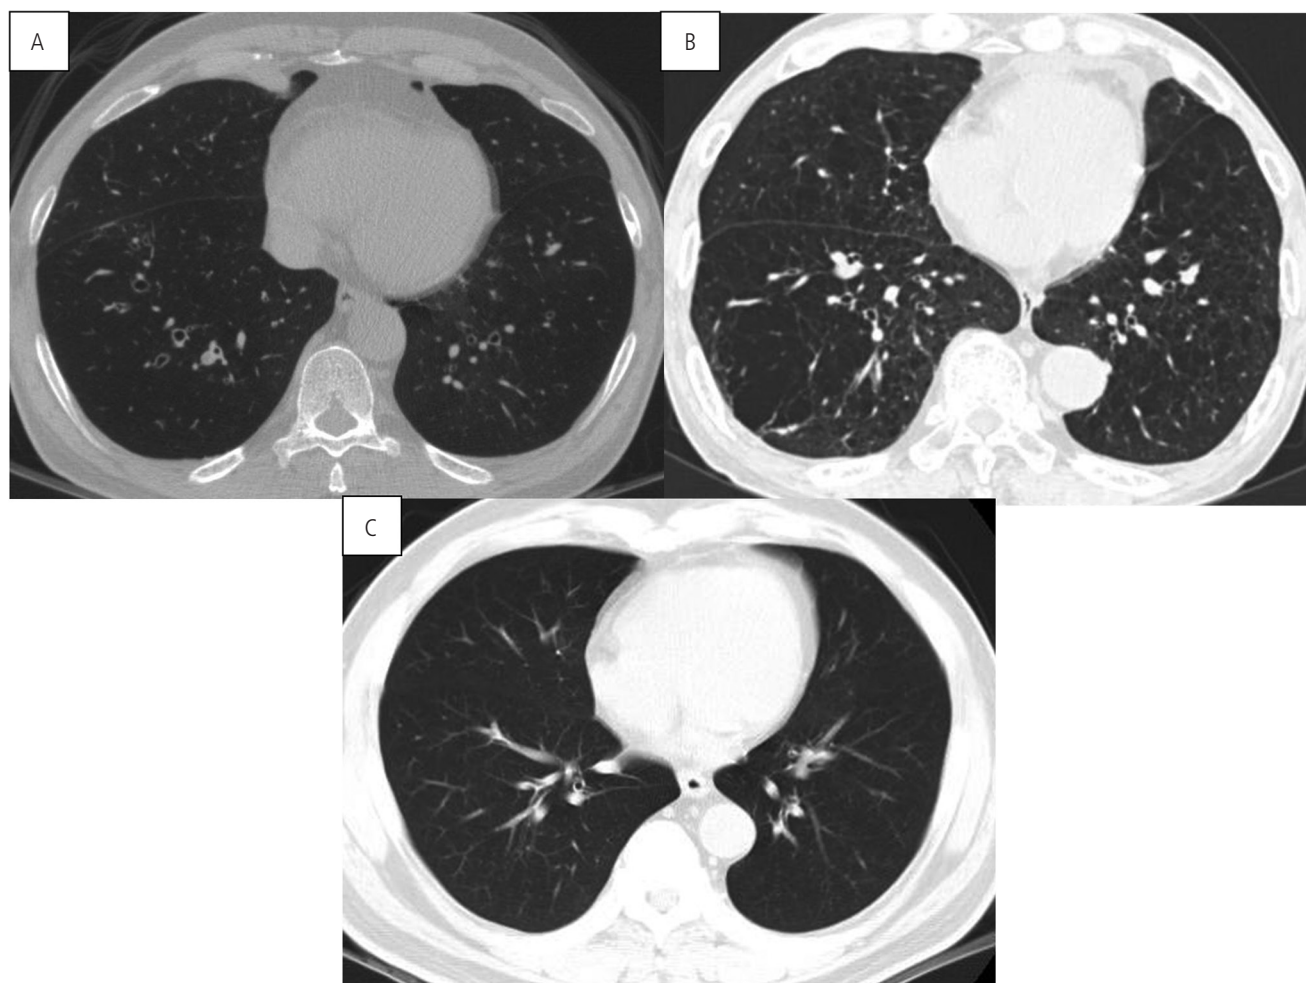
Representative computed tomography images of each phenotype. A, Large or medium airway remodeling. B, Small airway remodeling. C, Near-normal.
